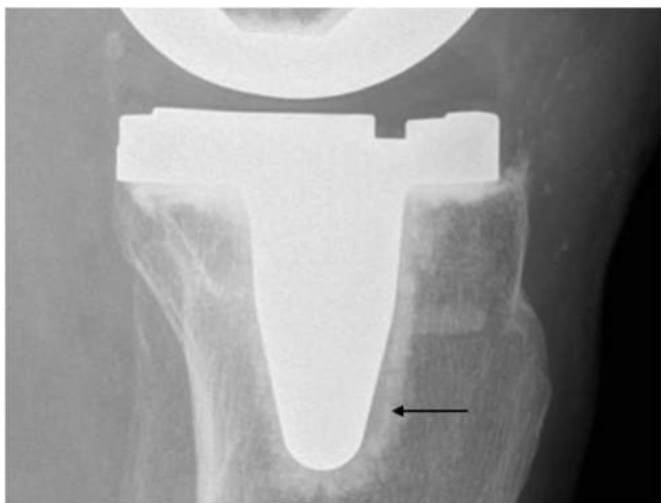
Attune radiograph showing lucency at the implant-cement interface in lateral zone 3.
